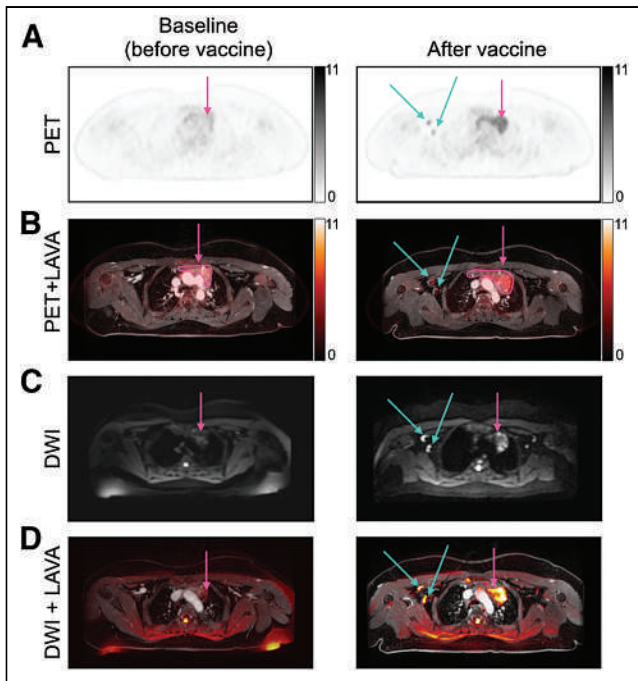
Axial ^{18}F -FDG PET (A), ^{18}F -FDG PET/T1-weighted gradient echo (LAVA) MRI (B), axial DW MRI (C), and DW MRI/LAVA MRI (D) in 14-y-old girl with bilateral ovarian Sertoli-Leydig tumors. Scans were obtained 3 mo before first COVID-19 vaccination dose (first column) and 2 mo after third vaccination dose (6 mo after first vaccination; second column). After vaccination, ^{18}F -FDG PET and ^{18}F -FDG PET/LAVA MRI showed increased uptake in thymus (pink arrows in A and B) and axillary lymph nodes (blue arrows in A and B); similarly, DW MRI and DW MRI/LAVA MRI showed restricted diffusion in thymus (pink arrows in C and D) and axillary lymph nodes (blue arrows in C and D). DWI = diffusion-weighted imaging; LAVA = liver acquisition with volume acquisition.
